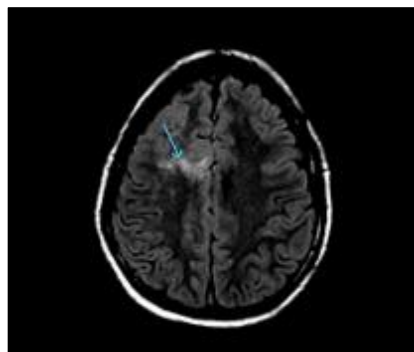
Axial FLAIR image of MRI brain at centrum semiovale level, showing irregular hyperintense foci in right anterior centrum semiovale, likely to represent microhamartomas or UBOs (sky-blue arrow)
